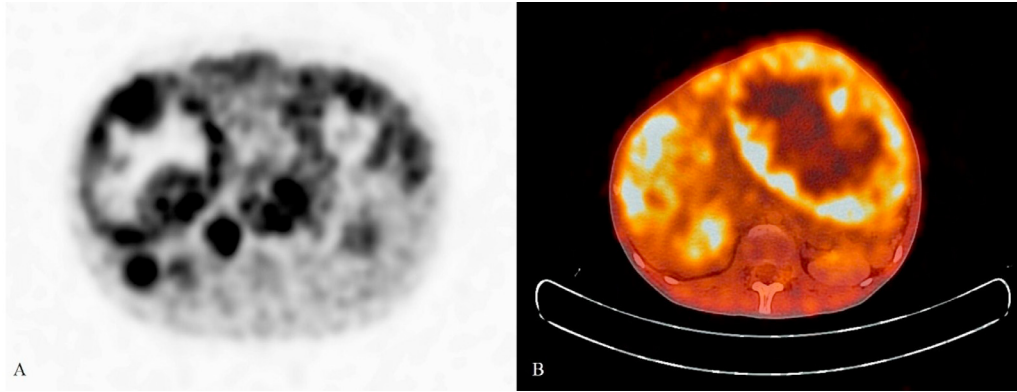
Hepatic epithelioid hemangioendothelioma: PET-CT axial showing pathologic 18F-FDG uptake in the hepatic lesions with characteristic peripheral uptake in the larger lesions in fused image (B).
